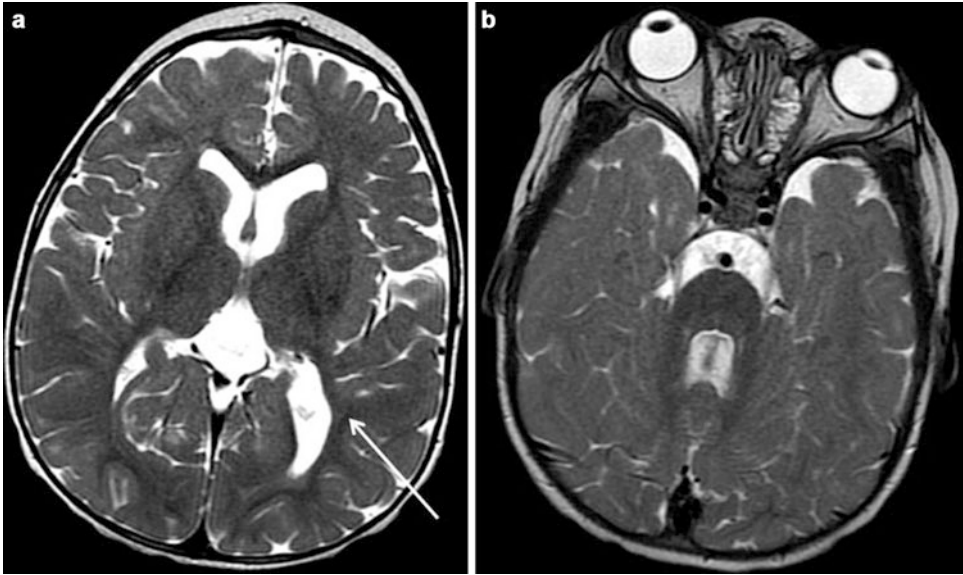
(a, b) MRI images of the brain obtained at 16 month of age showed hypoplasia of the parietooccipital white matter with undulating bilateral lateral ventricle
